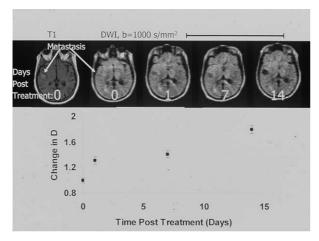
Diffusion imaging by diffusion weighted MRI (DW MRI): non-invasive characterisation of brain metastasis, sensitive to the diffusion of water molecules in the tissue, showing early changes in morphology and physiology of the metastasis 15 days after treatment: the lesion (arrows) starts from bright signal (slow water=metastatic tissue) to dark signal (fast water due to necrosis within the lesion) (courtesy of Y. Mardor, Israel [58]).
